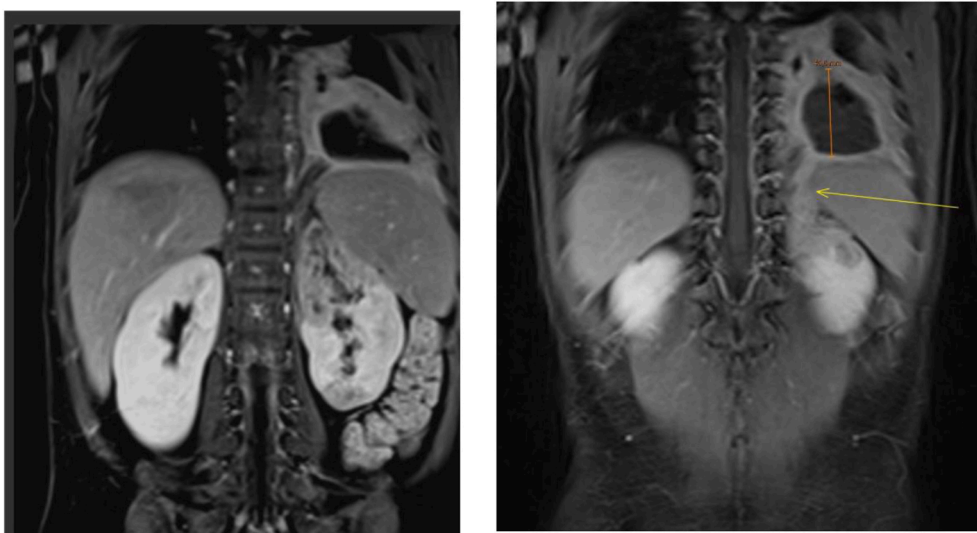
MRI after two weeks of conservative treatment with double J catheter, transurethral catheter and Meropenem: the upper pole and a lower pole segment of the left kidney show poor enhancement and atrophy. Nephro-pleural fistula marked with yellow arrow and abscess in pulmonary pleural cavity of 3.6cm diameter marked with orange line. (For interpretation of the references to colour in this figure legend, the reader is referred to the Web version of this article.)
